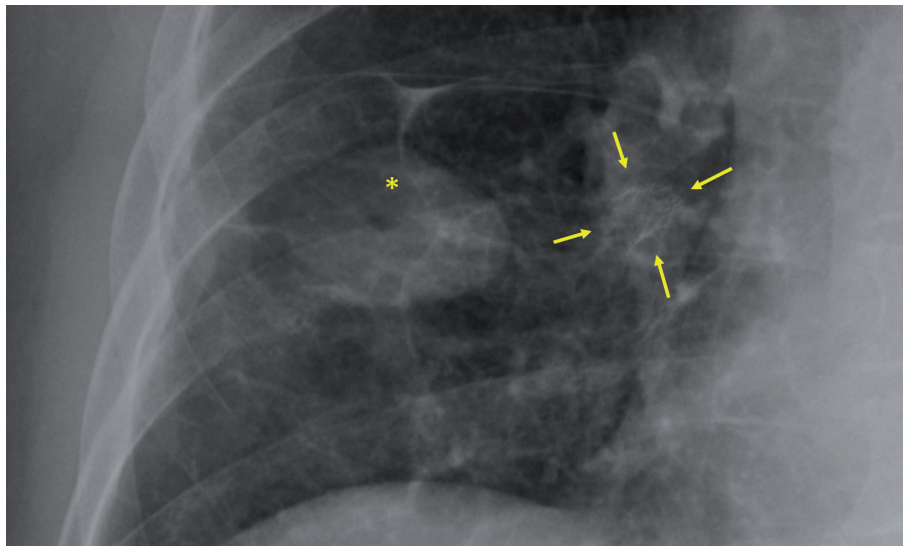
Resolution of pneumothorax after implantation of an endobronchial valve (faint metallic shadow surrounded by yellow arrows) for bronchopleural fistula. This is the same patient as Figure 7 And the ablation zone is marked by (*) on this chest x-ray.
